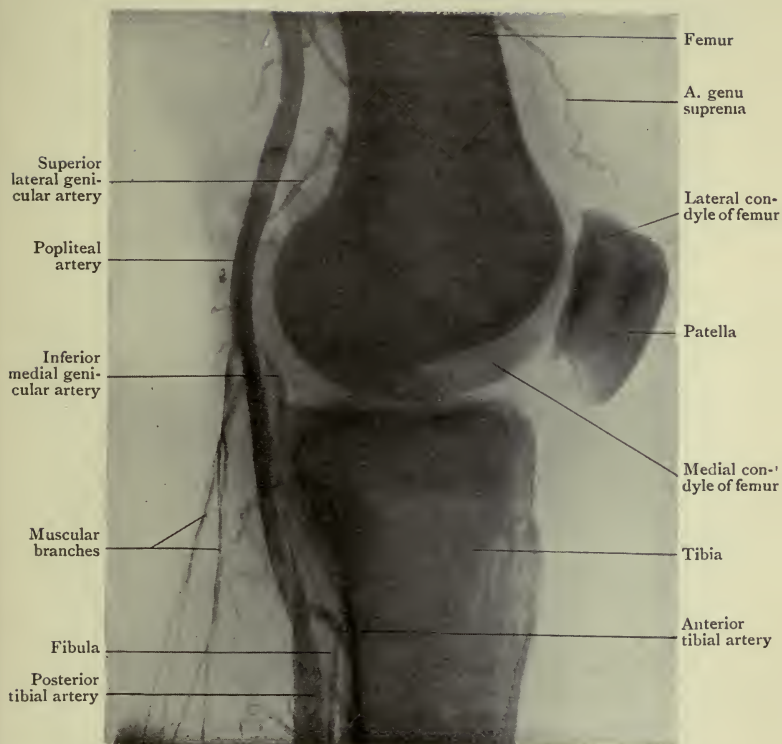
Radiograph of the Knee Region of an injected inferior extremity.
